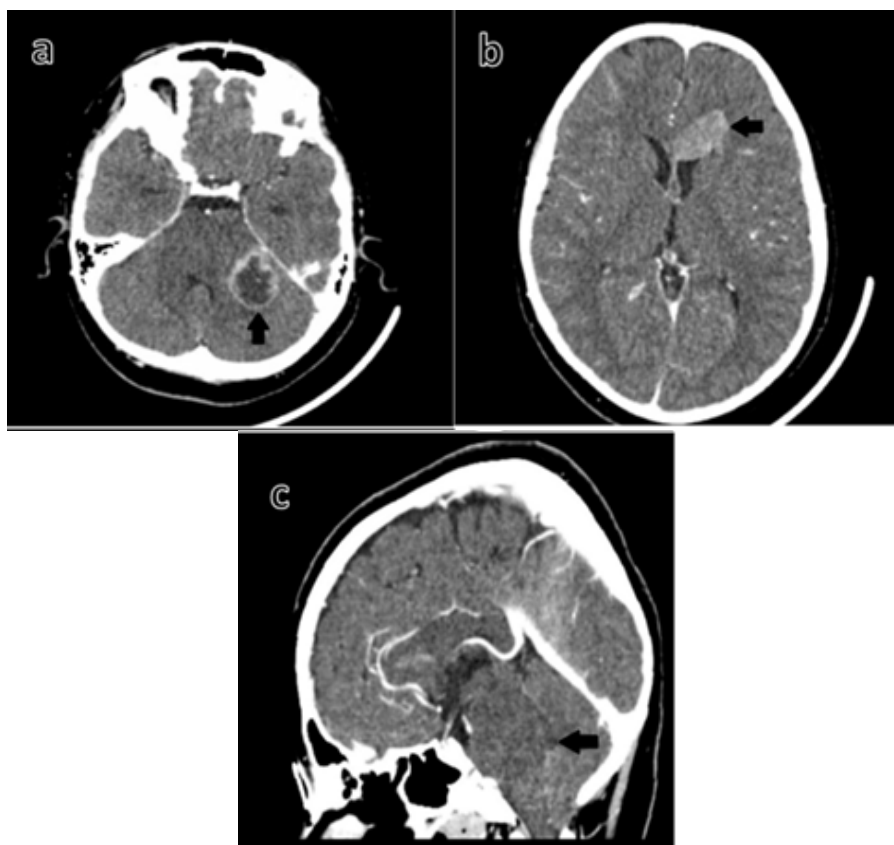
Initial computed tomography imaging. a) An expansive heterogeneous lesion with ring postcontrast enhancement in the middle level of the left cerebellar hemisphere. The lesion infiltrates the left cerebellar peduncle (black arrow). b) A hyperdense lesion with irregular edges and postcontrast enhancement at the level of the genu/anterior portion of the left corpus callosum (black arrow). c) The pons exhibits significant expansion (black arrow).
